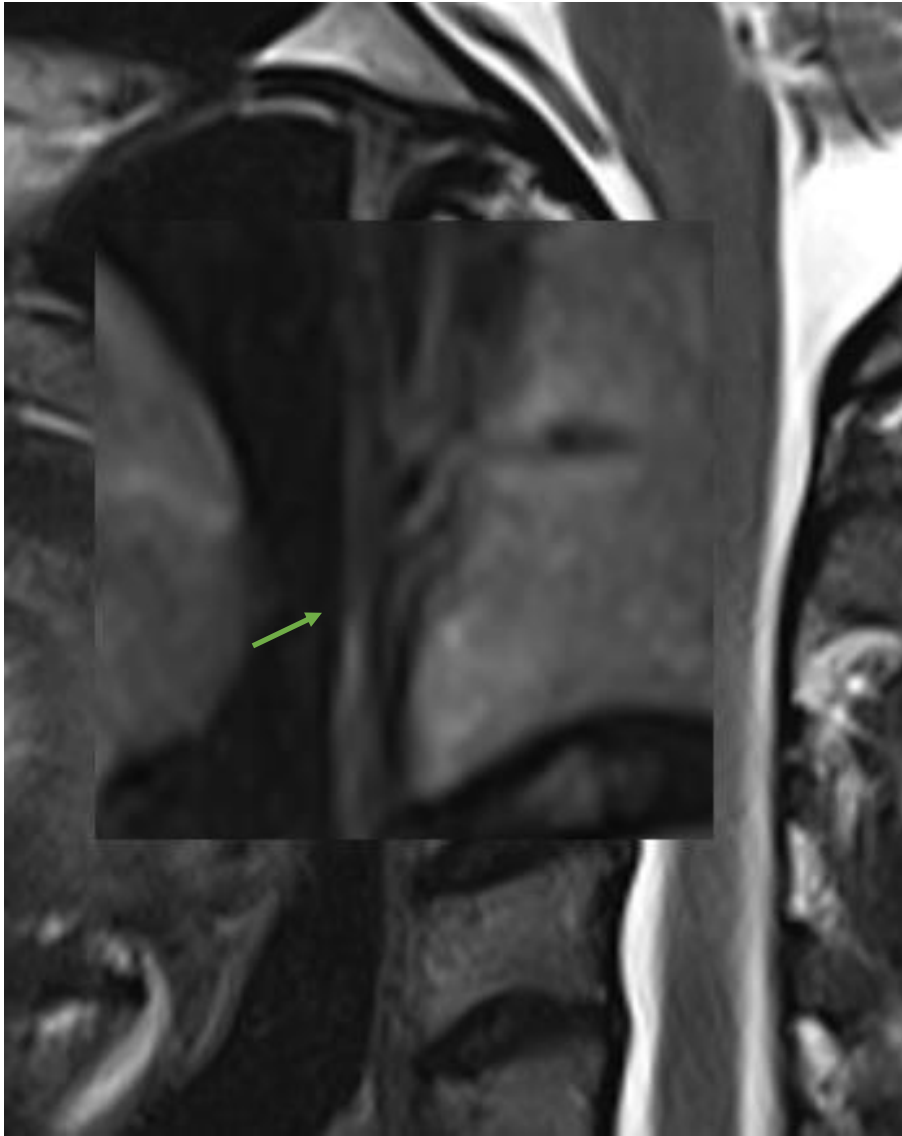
3T MRI, T2-weighted sagittal TSE at the level of the upper part of the dens axis-atlas. This picture shows the same enlarged section of the Anterior Longitudinal ligament as shown in figure 9.
